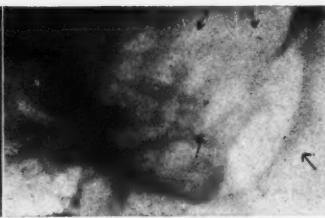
Roentgenogram of the temporal bone after the Stenvers method. Tuberculous caries of the pars mastoidea and of the pyramid. Both present areas of lesser density. The labyrinth can be distinguished very clearly. It is, however, surrounded by a thin fibrous coat.
